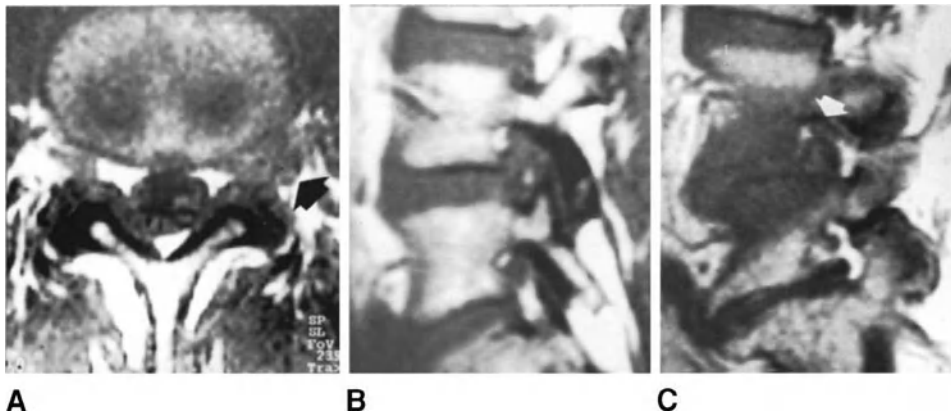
L4-L5 intraforaminal disc herniation on the left. The spin-echo T1-weighted axial image (A) shows a focal convexity in the left foraminal border of the disc which impinges on the L4 nerve root (arrow). The spin-echo T1-weighted sagittal images (B) and (C) show obliteration of the intraforaminal fat and compression of the L4 root (C), which is pushed against the pedicle (arrow). A free disc fragment, migrated into the intervertebral foramen, was detected at operation.
